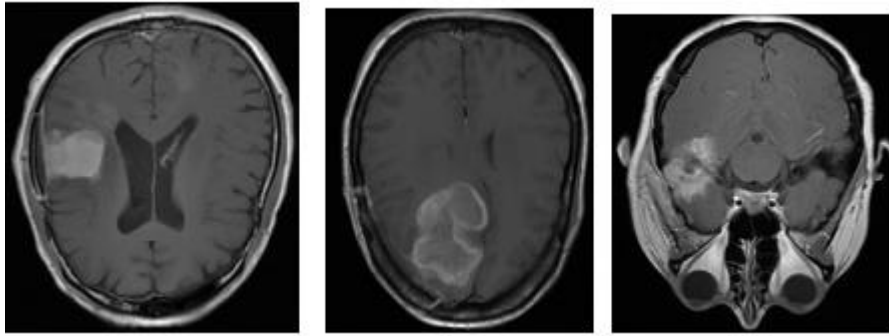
Typical Glioblastoma multiforme (grade 4 glioma) brain tumor axial T1-W contrast enhanced MRI scans.
